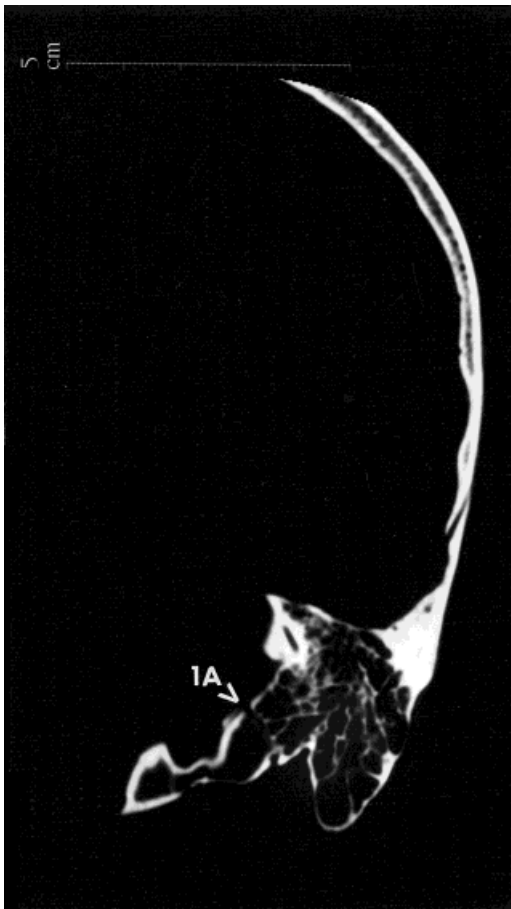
CT sections through the petroexoccipital articulation (HTH 989) joint not fused.
